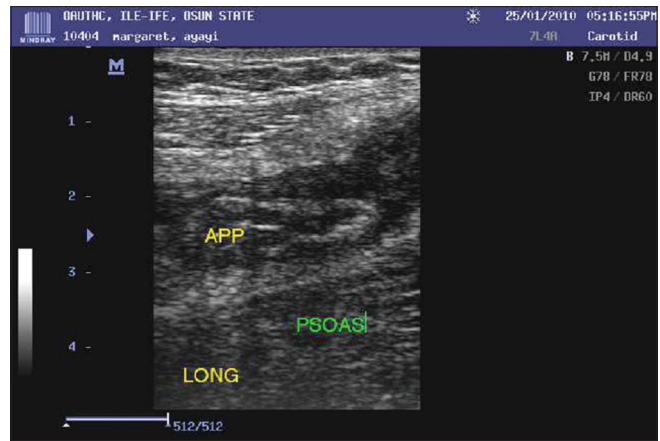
Longitudinal sonogram showing periappendiceal fluid collection in a ruptured appendix
